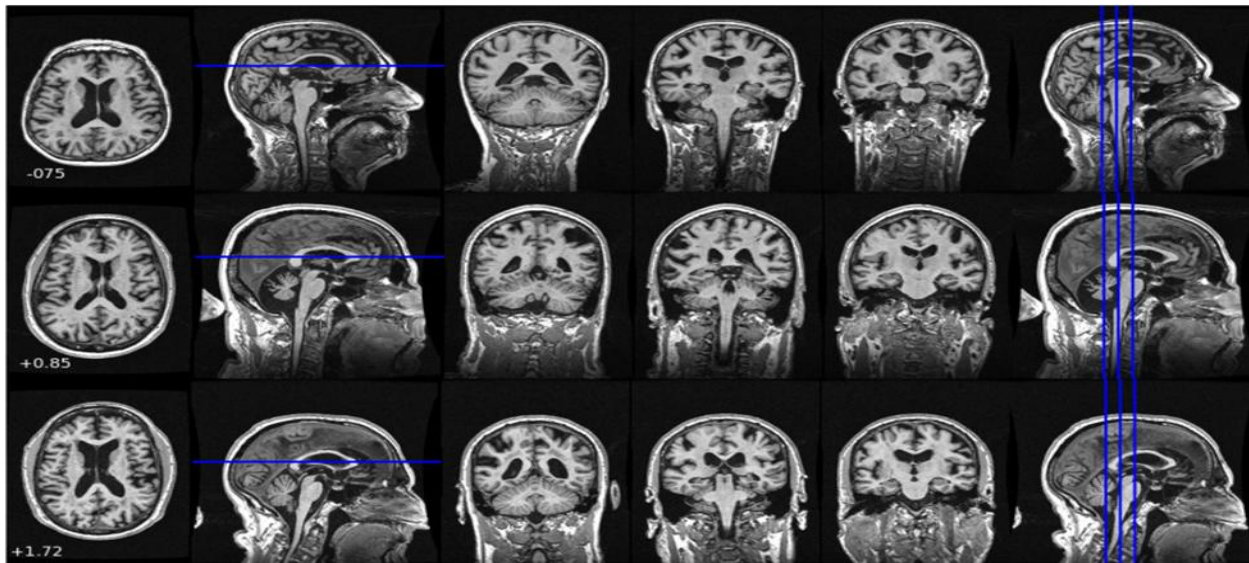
Sample MRI images considered for training and testing from various subjects
